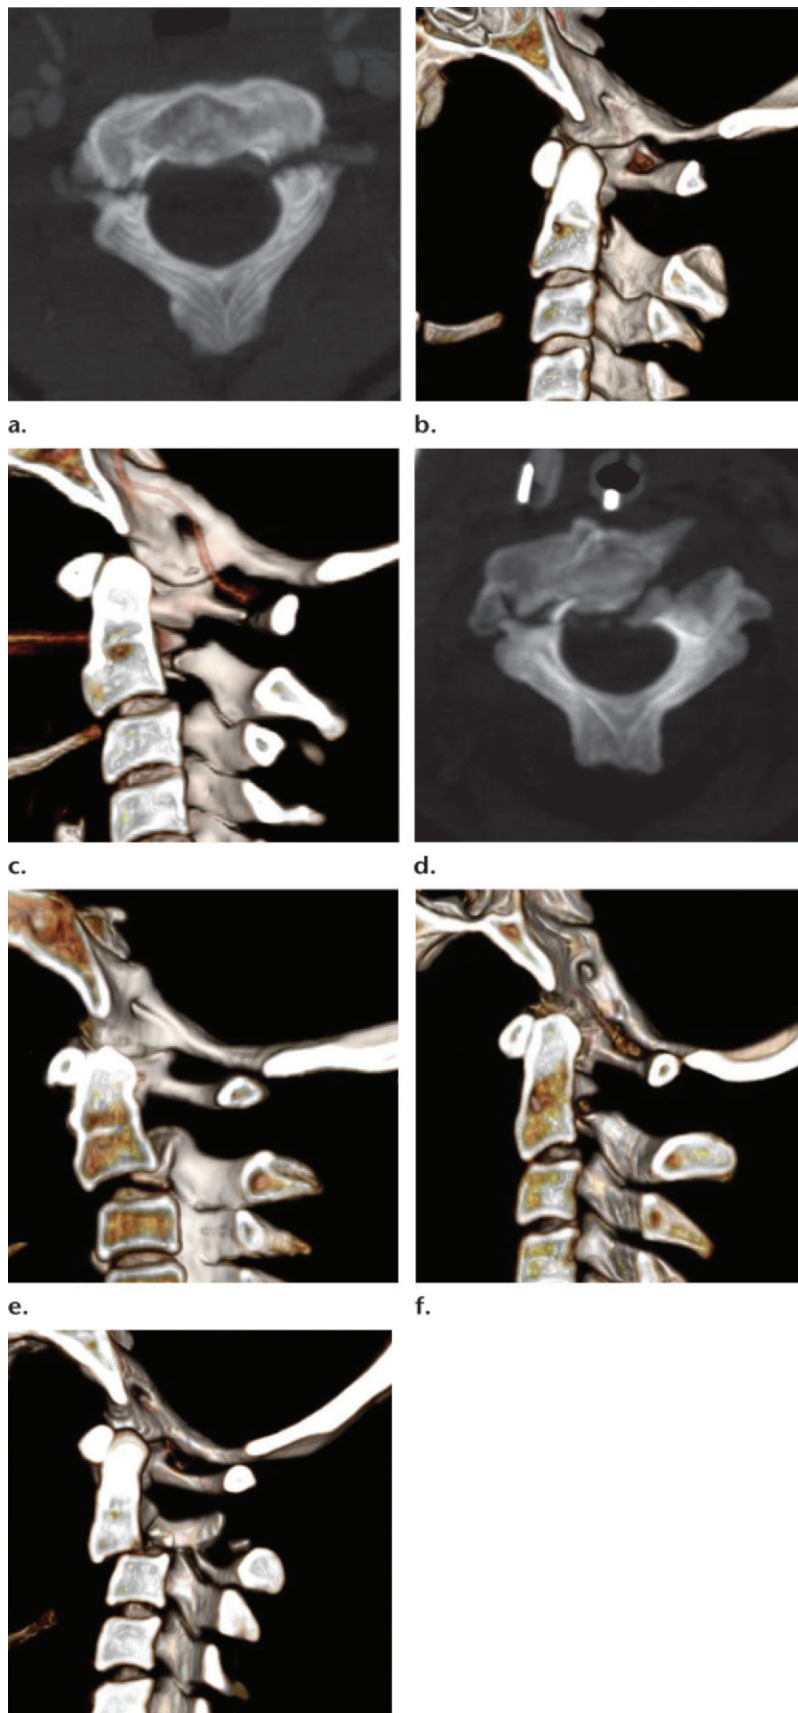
Hangman fractures in five patients. (a) Off-axial MIP image of an 18-year-old patient after a fall from an all-terrain vehicle shows a type I hangman fracture with bilateral fractures of the pars interarticularis. (b) Sagittal half-space slab volume-rendered CT image of an 18-year-old patient (same patient as in a) shows no translation or angulation of C2. (c) Sagittal half-space slab volume-rendered CT image of a 27-year-old woman with a type II hangman fracture after an MVC shows anterior translation and angulation of C2. The patient also had bilateral posterior arch fractures from hyperextension. (d) Off-axial MIP image of a 62-year-old woman with an atypical type II hangman fracture after an MVC shows a pars fracture on the right and an oblique fracture through the posterolateral vertebral body. (e) Sagittal half-space slab volume-rendered CT image of a 62-year-old woman (same patient as in d) shows anterior translation and angulation of C2 and a fracture involving the left vertebral body. (f) Sagittal half-space slab volume-rendered CT image of a 26-year-old woman with a type IIa hangman fracture after an MVC shows a pars interarticularis fracture with anterior angulation of the body of C2 but no anterior translation. No disruption of the anterior longitudinal ligament was depicted on MR images (not shown). (g) Sagittal half-space slab volume-rendered CT image of a 30-year-old woman with a type III hangman fracture after an MVC shows marked anterior translation of C2 with facet fracture-dislocation.
